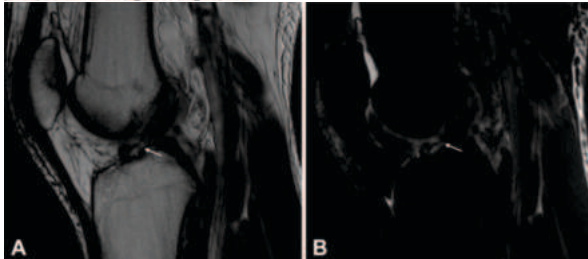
A type IV tear (arrow) is shown on the (A) sagittal T1-weighted view and (B) sagittal T2-weighted view.
